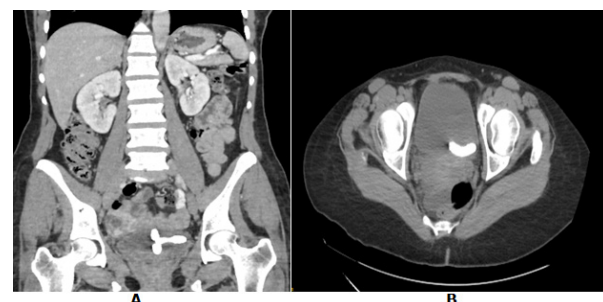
Computed tomographic scan showing a calcified IUCD in the urinary bladder.
